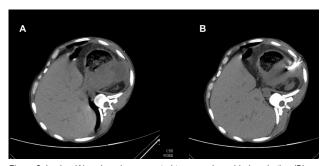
Lesion (A) undergoing computed tomography-guided aspiration (B).
